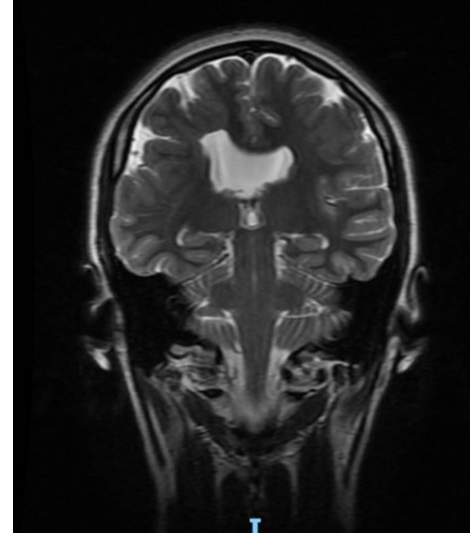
Simple magnetic resonance imaging of the brain with open lip schizencephaly and retraction of the right lateral ventricle.
